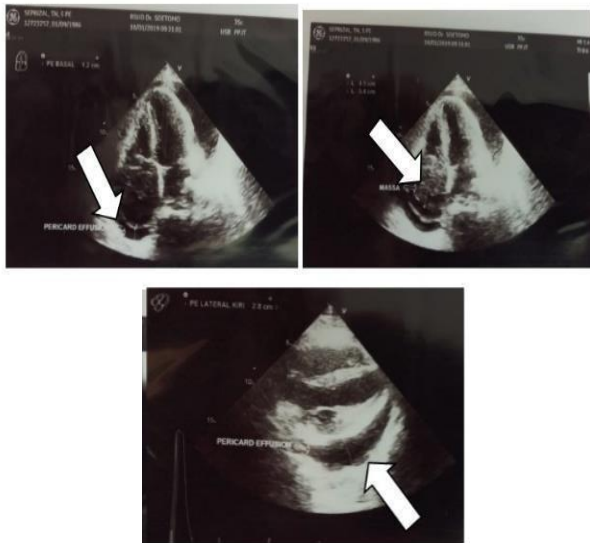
Echocardiography shows pericardial effusion and mass with differential diagnosis of thrombus tumors
